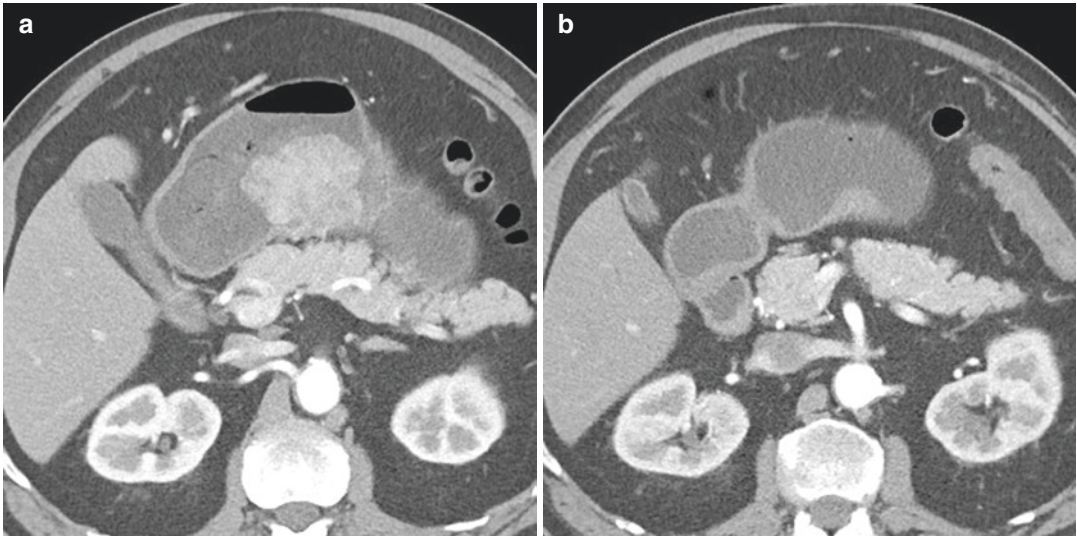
A patient with gastric mass found by upper endoscopy. Biopsy revealed moderate to poorly differentiated adenocarcinoma. (a) Axial contrast-enhanced arteria phase CT shows an enhancing polypoid mass in the gastric body measuring 4.3 × 5.8 cm. (b) CT performed 2 months after chemotherapy with FLOT regimen
